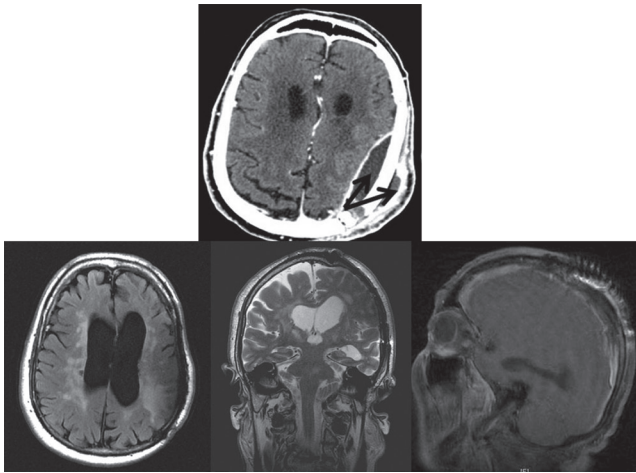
Contrast enhanced computed tomography at the time of second patient's admission. A collection of purulent material was immediately evident in the subcutaneous and epidural compartments (black arrows). Underlying brain sulci are compressed. Pre-cranioplasty magnetic resonance imaging, showing no further contrast enhancement of the meninges and full brain re-expansion.
